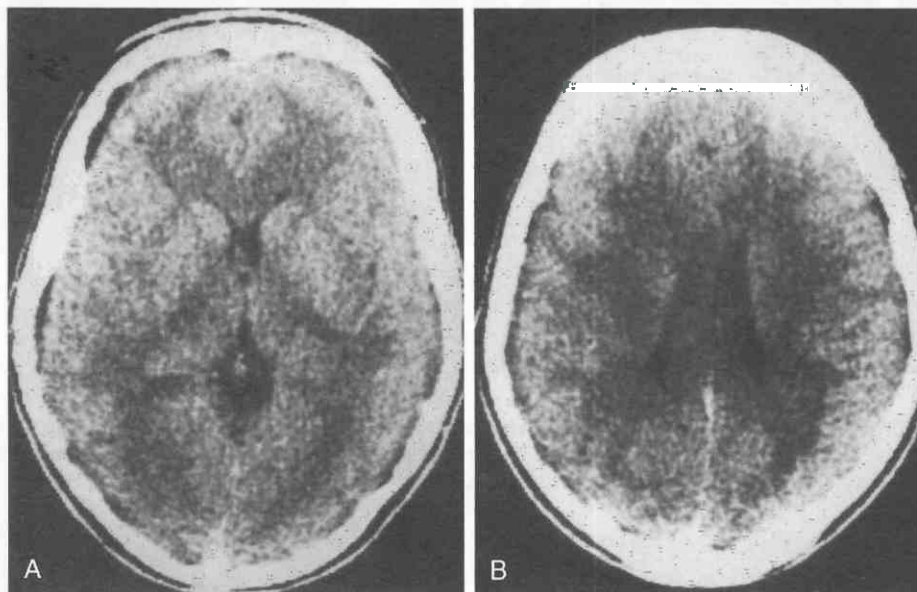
Multiple sclerosis, acute phase, in a 19-year-old woman with extremity numbness, difficulty in walking, blurred vision, and slurred speech. A–C, Precontrast CT sections are abnormal, with diffuse, patchy hypodensity of the white matter.
